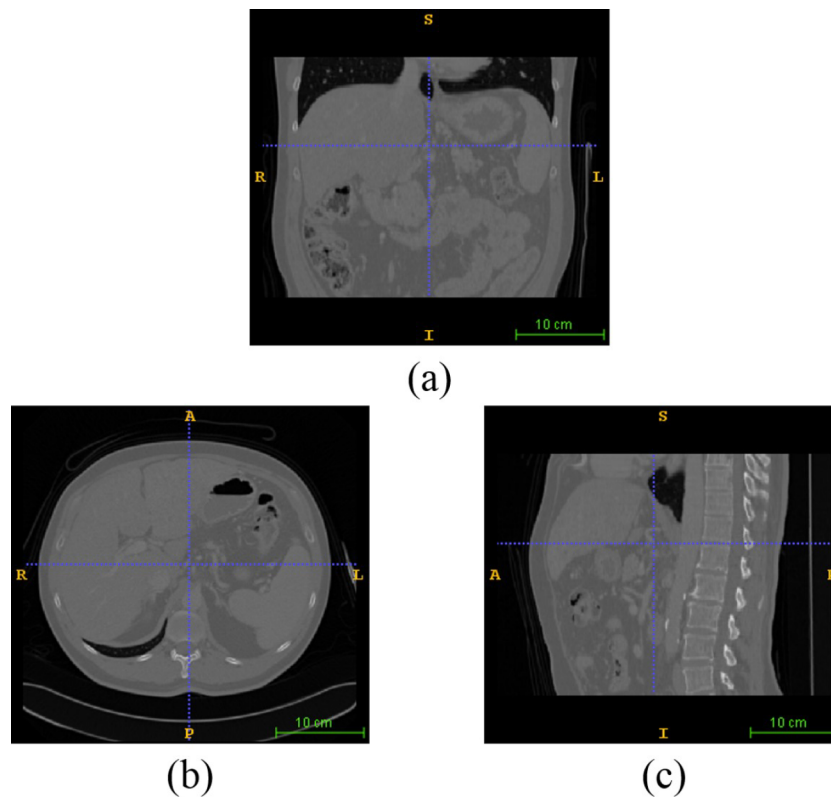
A clinical CT image. (a)–(c) show livers in different planes. (a) Transverse plane; (b) sagittal plane; (c) coronal plane. The liver in CT image has blurry margin and low gray contrast to the adjacent organs.
